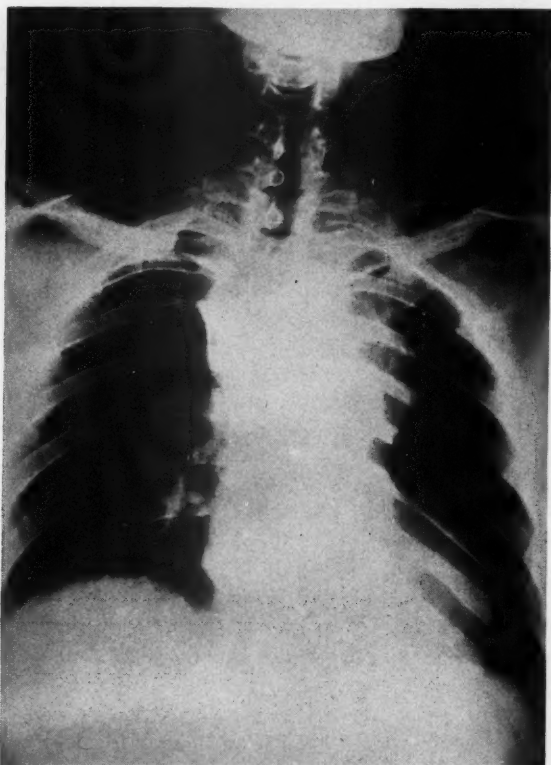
Preoperative roentgenogram of the chest showing large calcified mass in the superior mediastinum (aneurysm).
